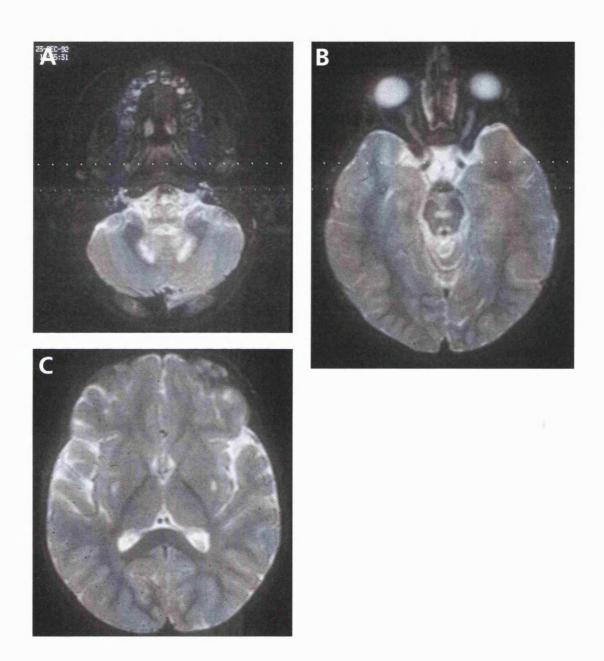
MRI brain of P27
